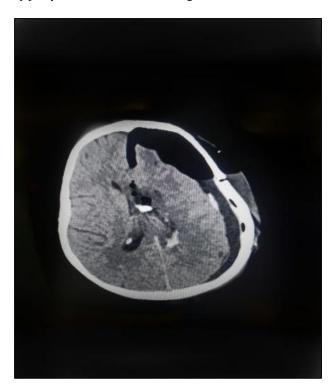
Post operative MRI indicating a left functional hemispherotomy.
